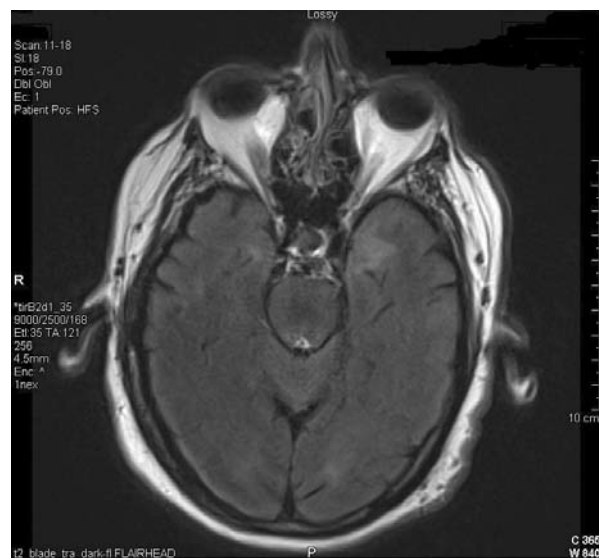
T1-weighted magnetic resonance image of the patient's brain showing a focus of abnormal signal in left anteromedial temporal lobe.
